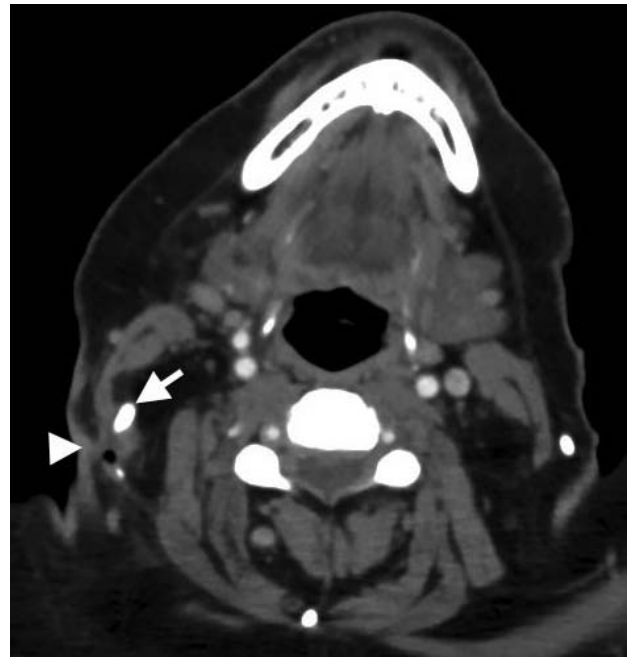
Preoperative CT of the neck. Image shows a 3 × 2 cm lesion (white arrowhead) abutting the residual VPS tubing (white arrow) in the area deep to the SCM muscle in the right neck.
